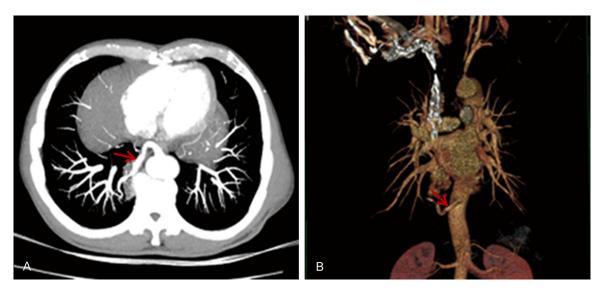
Contrast-enhanced CT scanning with three-dimensional reconstructions showing the aberrant artery originating from the descending thoracic aorta.
